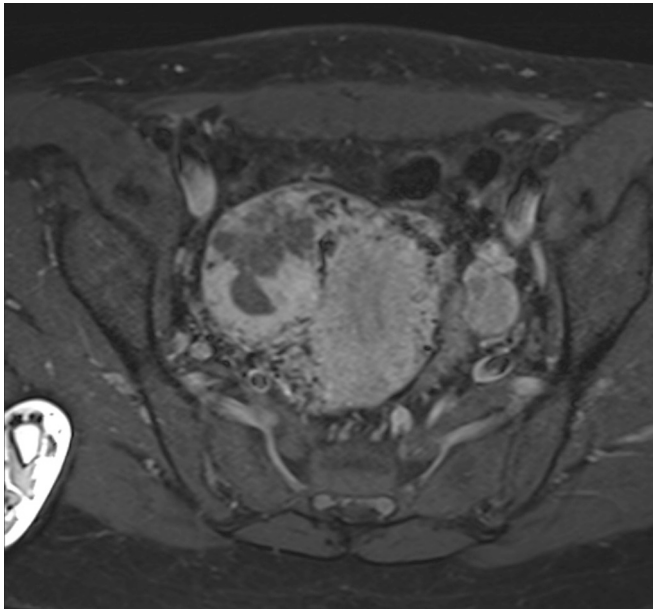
Axial fat-saturated T1-weighted MRI sequence, after administration of IV gadolinium. This demonstrates a peripherally enhancing solid-cystic mass measuring $3.5 \times 3.8 \times 4.2$ cm. It is located in the right uterine body myometrium and is partially subserosal. Vascularity was not concerning for an arteriovenous malformation.
